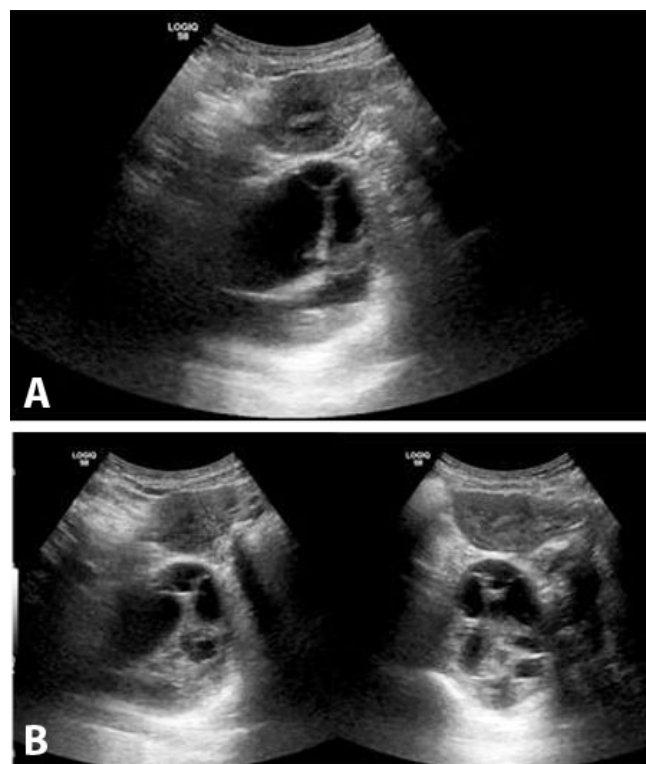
Ultrasound images (A) and (B) showing a large heterogeneous right adnexal mass with loculations.
